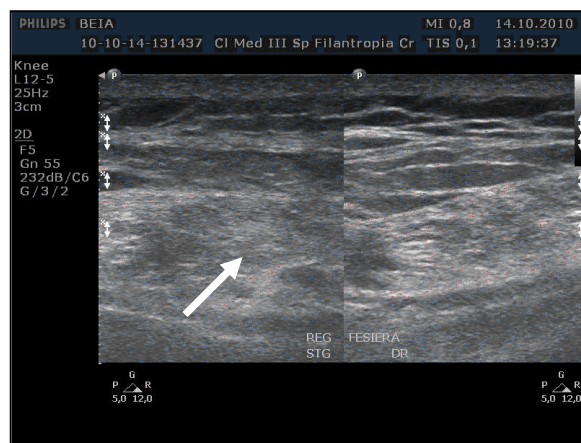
Ultrasound aspects for the gluteal area. Scratchy hyperechoic aspects in the left gluteal area (white arrow).
